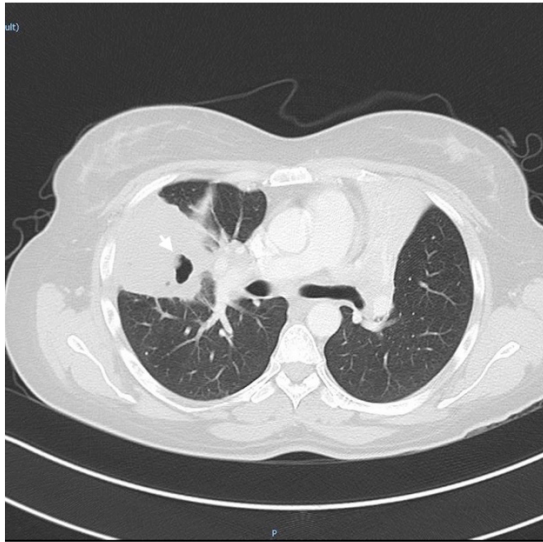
CT thorax shows consolidation and nodular pulmonary lesions with cavitation of the middle lobe consolidation (white arrow).
